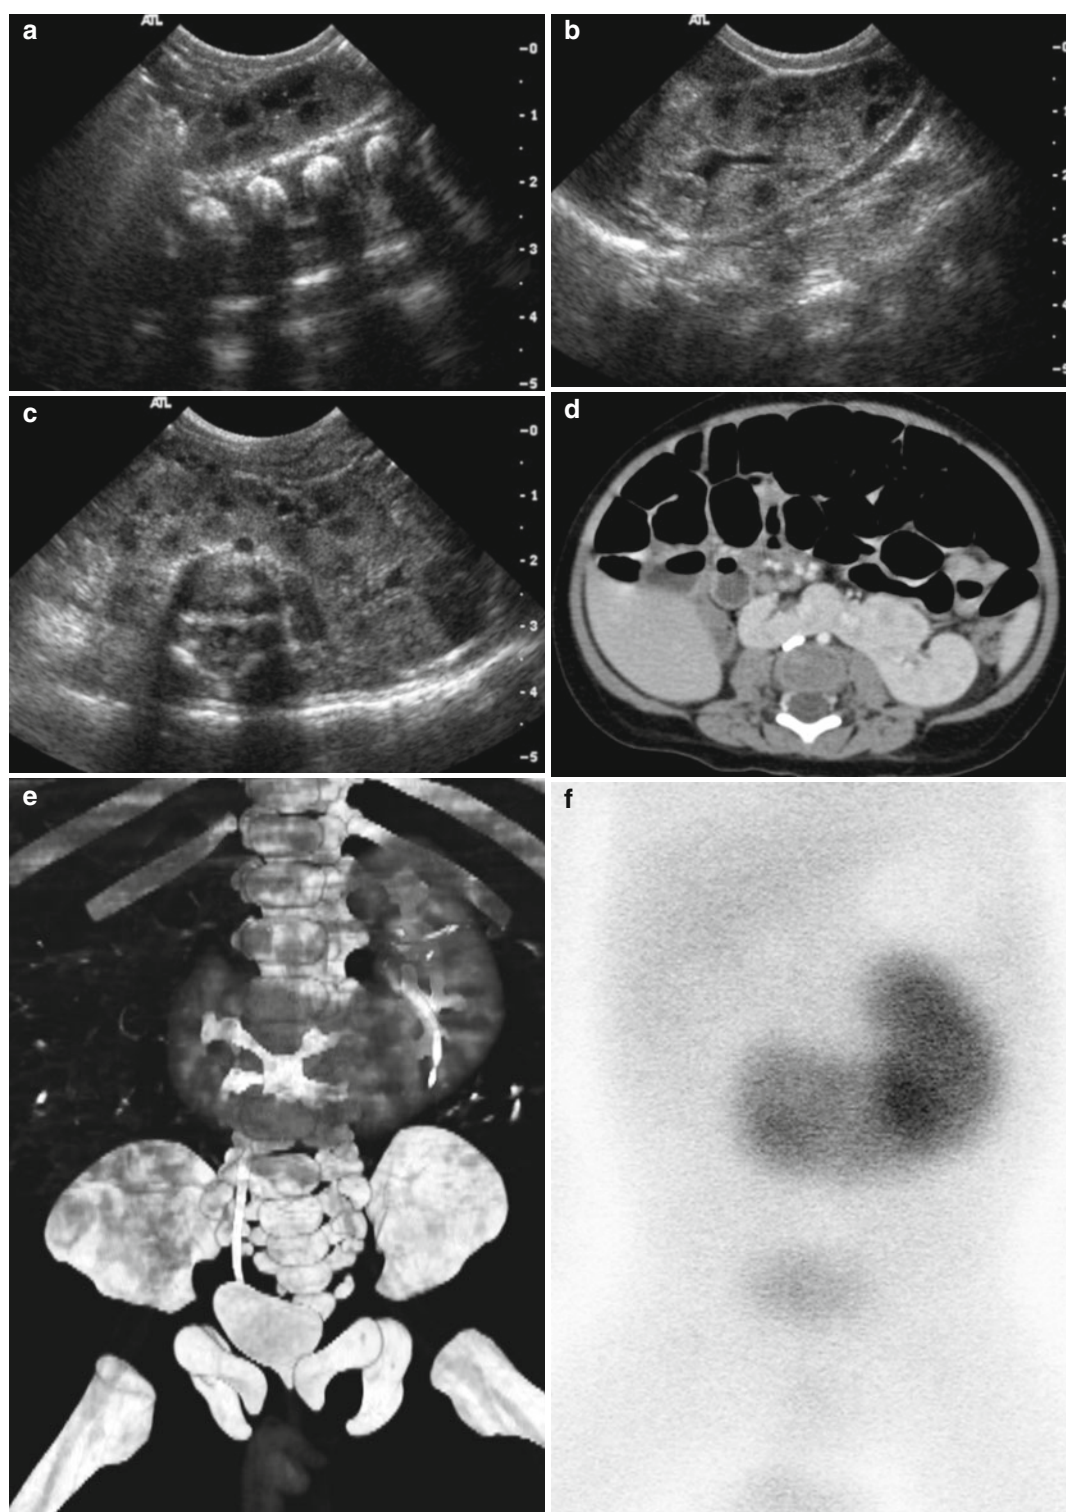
Crossed fused ectopy in a 5-month-old boy. (a)* Abdominal US of right renal fossa shows relatively small volume of right kidney. *(b)* US image of left abdomen shows grossly normal left kidney in left renal fossa. *(c)* Transverse US image of mid abdomen demonstrates fused portion of kidney anterior to aorta. *(d)* Contrast-enhanced CT scan of mid abdomen shows crossed ectopy of right kidney in midline
